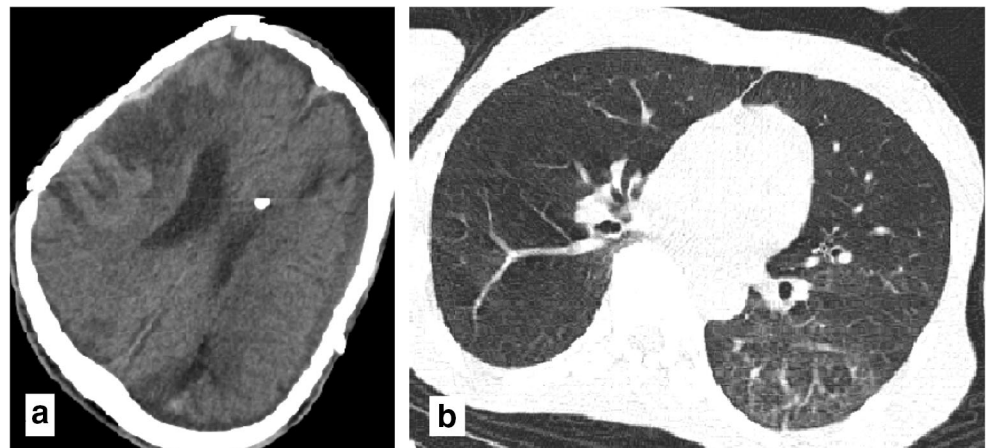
Thirty-three-year-old female with fever and reduced level of consciousness who had a history of exposure to known case of COVID-19 in his family. a Left MCA territory hypodensities in brain CT scan (a) and increased signal of cortex, white matter, head of left caudate, lentiform nuclei, and anterior horn of internal capsule in T2 and FLAIR brain MRI sequences (c, d), in favor of subacute infarct. b Small subpleuroal consolidation in superior segment of right lung inferior lobe highly suggestive for COVID-19
